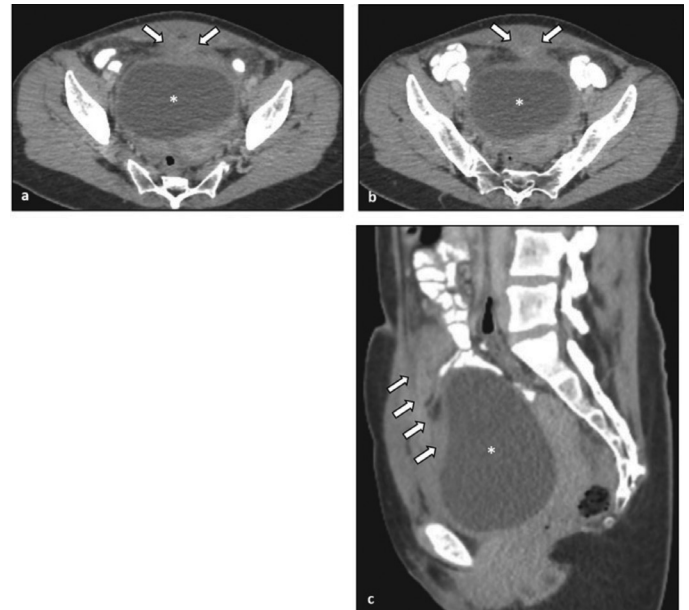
On axial (a, b) and sagittal (c) intravenous contrast-enhanced CT images passing through two different levels, a thick-walled appearance is seen in the anterior segment of the bladder (*), with a heterogeneous contrast-enhancing mass lesion (arrows) of approximately 60x20 mm size that cannot be clearly distinguished from the bladder wall and extends cranially toward the anterior abdominal wall, with an invasive appearance into the rectus muscle, without a distinctive shape
